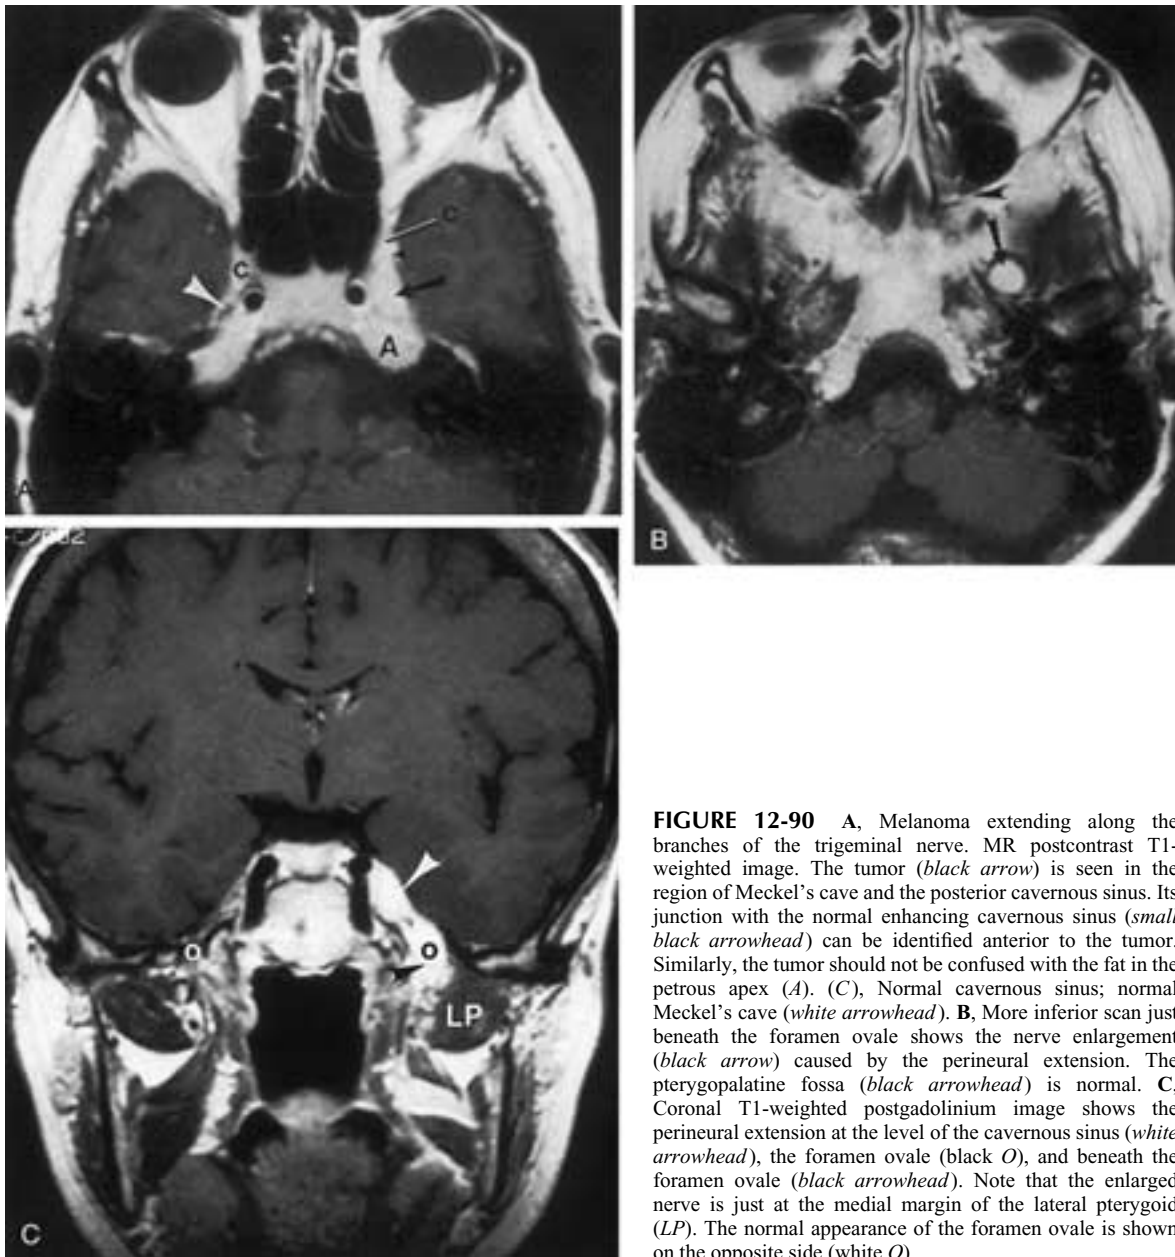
A, Melanoma extending along the branches of the trigeminal nerve. MR postcontrast T1-weighted image. The tumor (*black arrow*) is seen in the region of Meckel's cave and the posterior cavernous sinus. Its junction with the normal enhancing cavernous sinus (*small black arrowhead*) can be identified anterior to the tumor. Similarly, the tumor should not be confused with the fat in the petrous apex (*A*). (*C*), Normal cavernous sinus; normal Meckel's cave (*white arrowhead*). B, More inferior scan just beneath the foramen ovale shows the nerve enlargement (*black arrow*) caused by the perineural extension. The pterygopalatine fossa (*black arrowhead*) is normal. C, Coronal T1-weighted postgadolinium image shows the perineural extension at the level of the cavernous sinus (*white arrowhead*), the foramen ovale (*black O*), and beneath the foramen ovale (*black arrowhead*). Note that the enlarged nerve is just at the medial margin of the lateral pterygoid (*LP*). The normal appearance of the foramen ovale is shown on the opposite side (*white O*).
